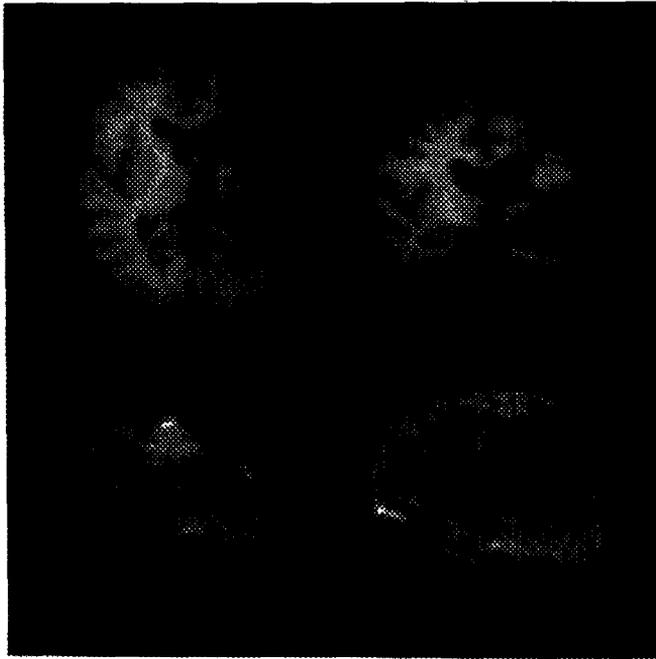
Three-dimensional reconstruction of Patient AK's lesion. This reconstruction depicts the extent of the middle cerebral artery infarction in this patient with a severe Broca's aphasia. The upper left image is a horizontal slice similar to those seen in CT images. The upper right image depicts a coronal section, and the lower left, a sagittal section through the left hemisphere. The lower right template shows a 3-D reconstruction of the brain with the lesion apparent on the lateral surface of the left hemisphere.
